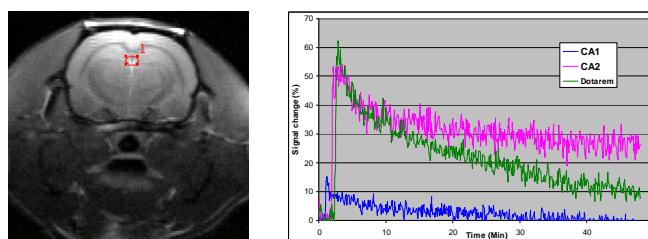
Representative gradient echo image (left) shows the location of measured time course. Time course of MRI signal intensity (right) in the brain artery during with CA1, CA2 and Dotarem (dose 0.04 mmol Gd /kg of body weight).
